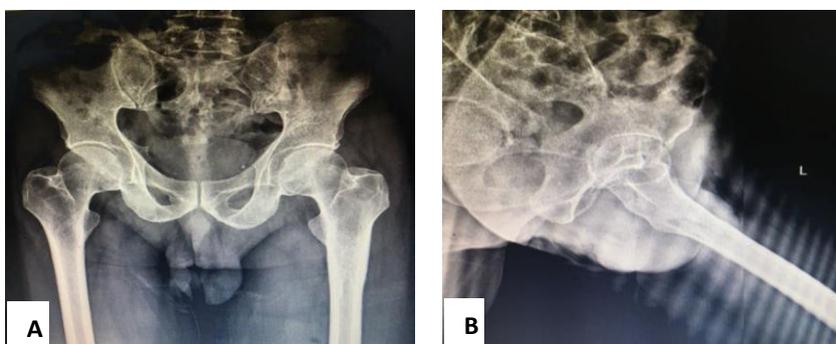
A: Plain Radiograph of pelvis with both hips AP view showing cystic lesion in proximal femur Left side (Arrow). B: Plain Radiograph of Left hip Cross table Lateral view.
